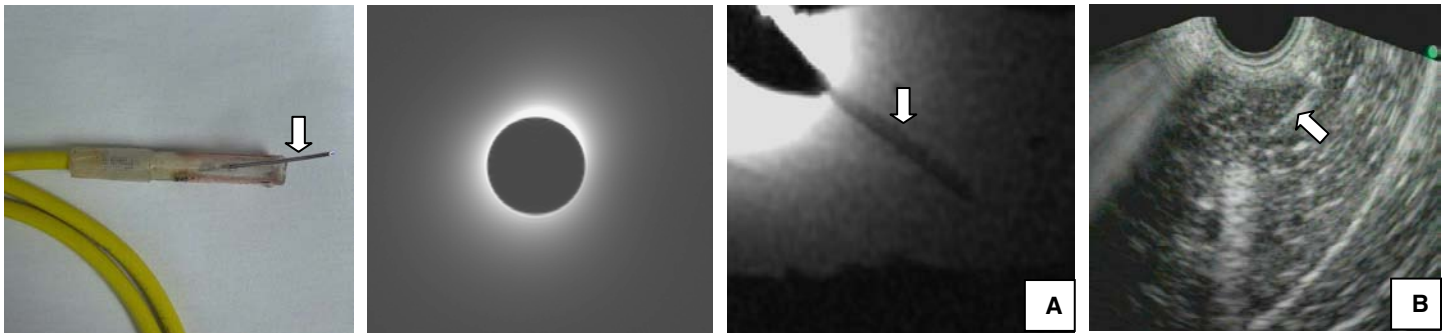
Endo-MRI coil. The outlet of the instrument channel was built within the center of the MRI coil. The arrow shows the fine needle.
